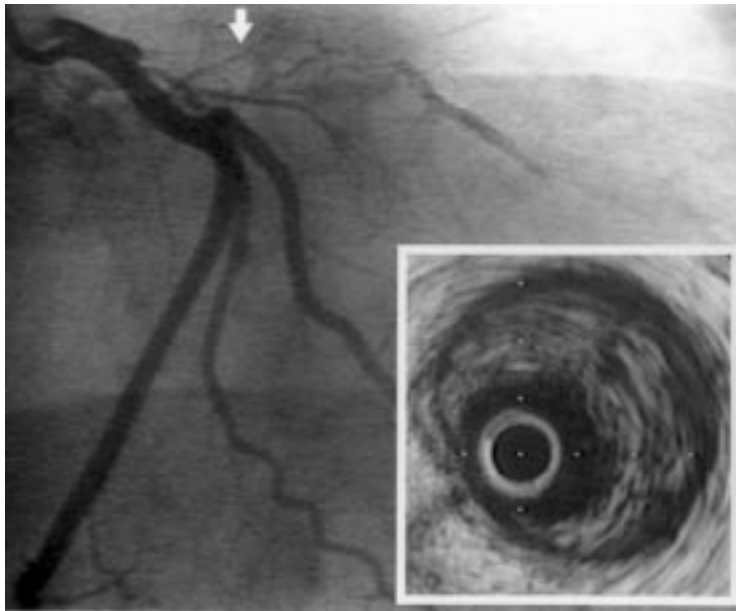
Coronary angiogram in the right anterior oblique projection of case 2 showing proximal occlusion of the left anterior descending artery and decreased filling distally. Inset, intravascular ultrasound image of the proximal left anterior descending artery (site indicated by arrow) showing extensive intraluminal thrombus.
